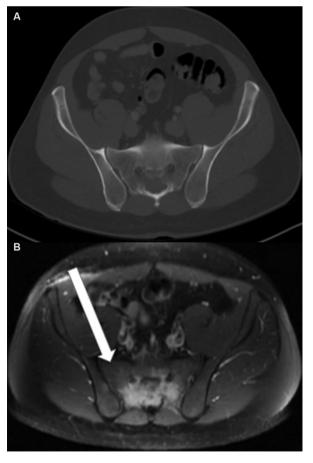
CT (A) and MRI (B) of the pelvis without visible sacral lesion (arrow).
